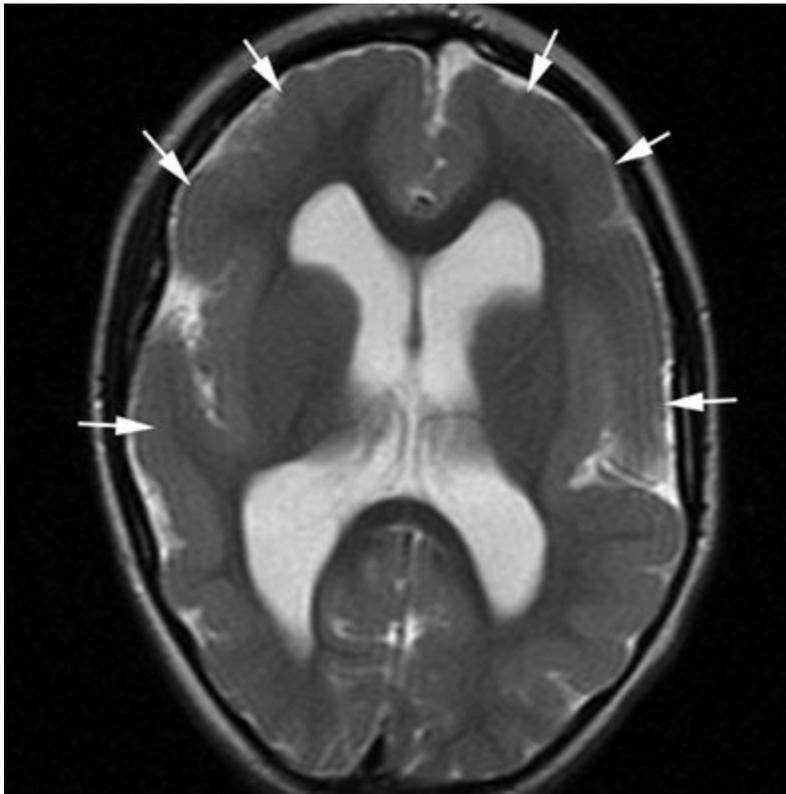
Pachygyria. Axial T2-weighted image from MRI without gadolinium in a 4-year-old with spastic quadriplegia and generalized seizures shows a paucity of sulcal markings and thickened cortex bilaterally (arrows).
